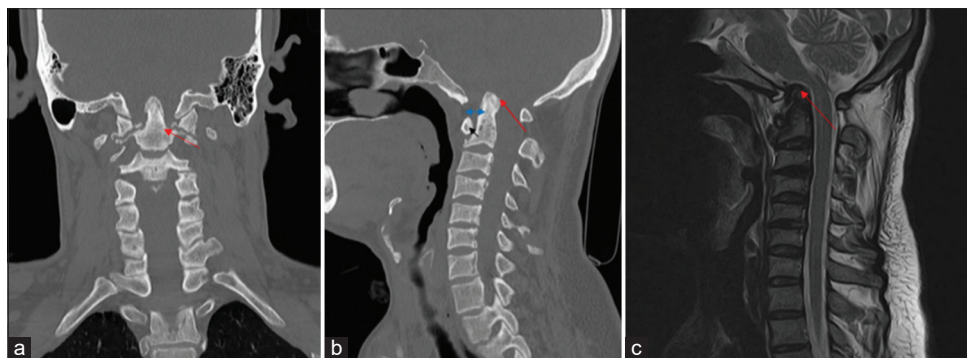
(a) Coronal computed tomography (CT) image of neck showing upward migration of odontoid process with basilar invagination (red arrow) “pencil tip abnormality;” (b) Sagittal image of CT neck showing upward migration of odontoid process (red arrow) crossing the Chamberlain line (black dotted line) for >3 mm, suggesting basilar invagination. The image also shows normal atlanto-axial distance (<3 mm, blue double-headed arrow) and presence of erosions over the C2 vertebral body (black arrow); (c) Corresponding midline sagittal image of magnetic resonance imaging cervical spine T2-weighted sequence showing upward migration of odontoid process compressing cervico-medullary junction (red arrow)
